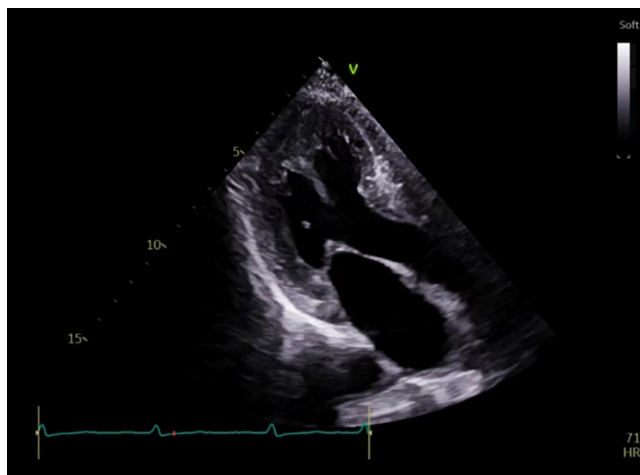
The echocardiography revealed a thickened ventricular septum (13 mm) with preserved ejection fraction (67%).
